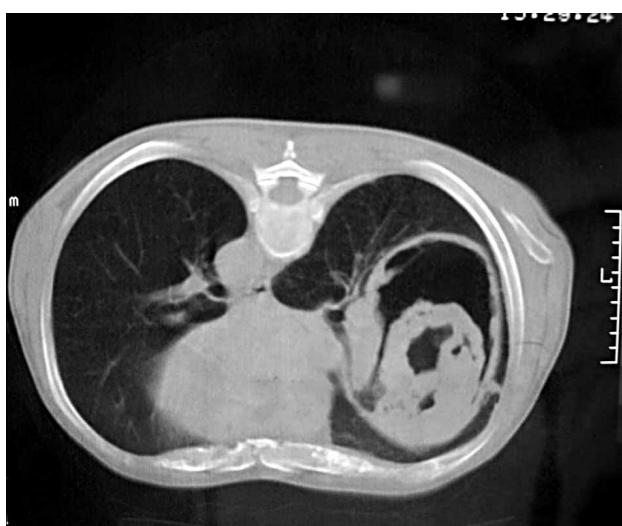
Thorax CT showing abscess cavity (15x10x9 cm), filled with mobile amorphous hyperdense mass (pathognomonic for aspergilloma).
